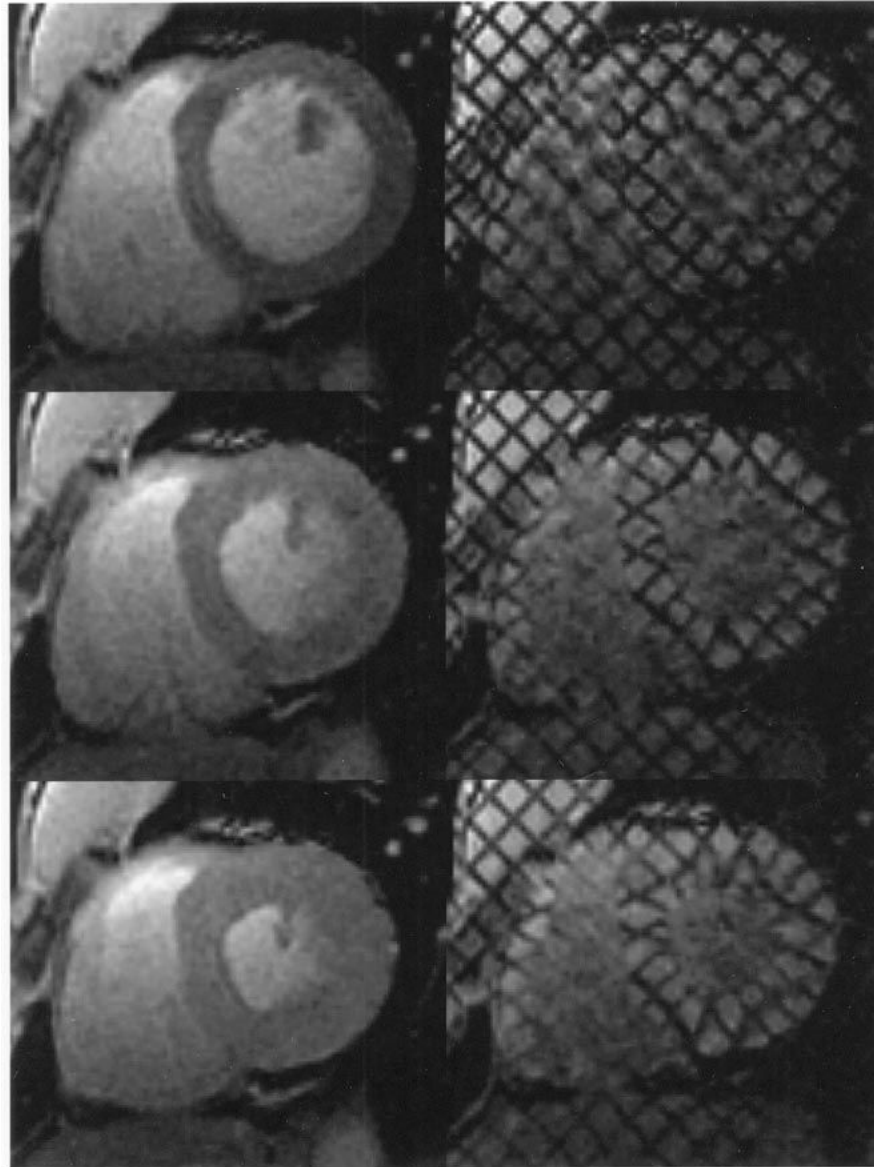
Left: standard cardiac MR images. Right: for the same heart, location, and cardiac phase, the corresponding tagged MR images. Top: at end-diastole, when the ventricular cavity is at its maximum filling, right after tagging. Middle: At mid-systole, when the heart is contracting. Bottom: at end-systole, when the maximum amount of blood has been ejected and the heart muscle is at its maximum contraction.
